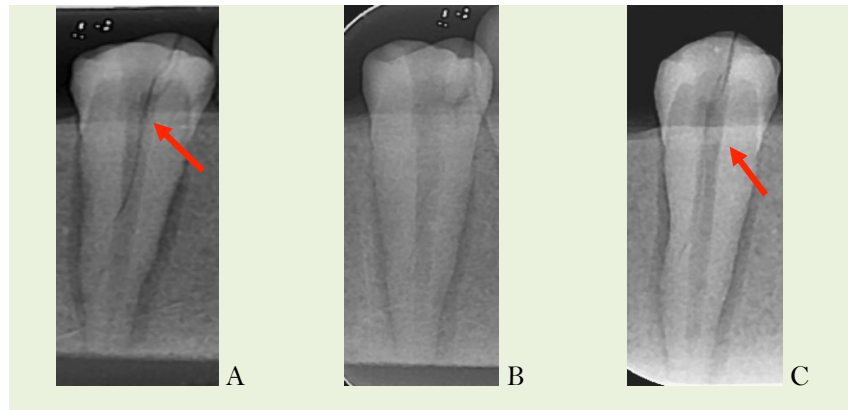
Digital radiography with: A) Parallel, B) Mesial and C) Distal angles.
